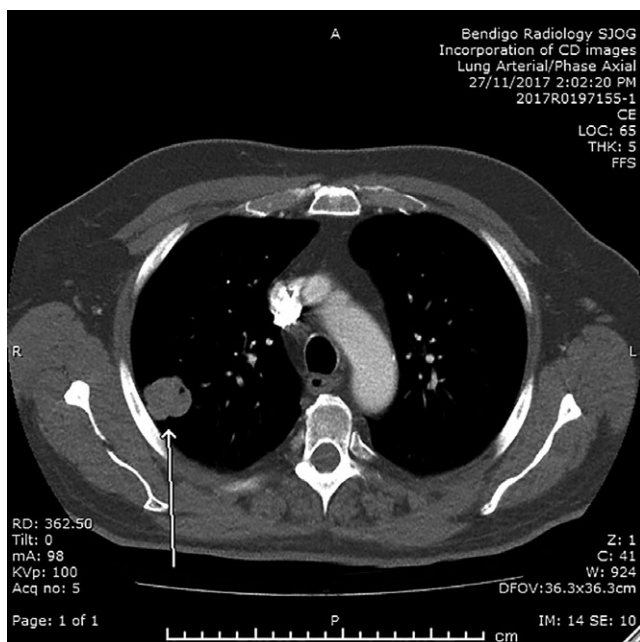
Axial CT of the chest showing a suspicious lesion in the right lung, which could represent a pulmonary metastasis from oral cancer, but could also represent a synchronous new lung cancer.
